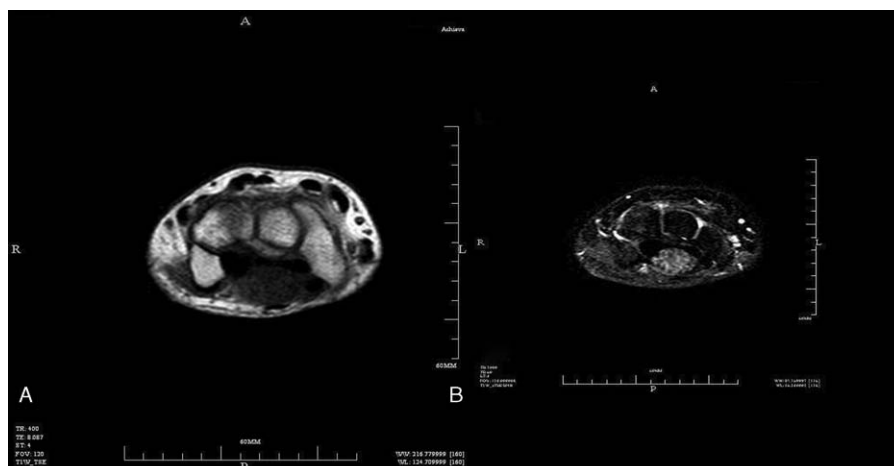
Preoperative MR of the lesion. (A) The mass showed low to intermediate signal intensity on T1-weighted images, (B) high signal intensity on T2-weighted images. MR = magnetic resonance.
